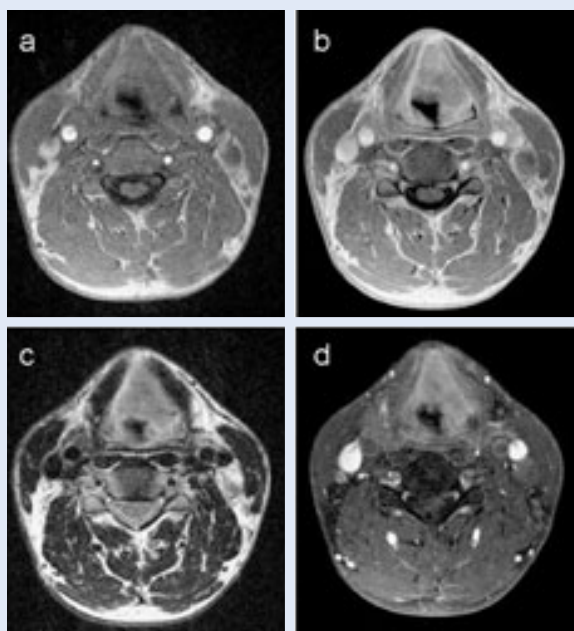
Axial MRI scan through the supraglottic larynx, all images show the same scan position. The images demonstrate a large supraglottic tumor infiltrating the preepiglottic space, the left paraglottic space and the left aryepiglottic fold.
